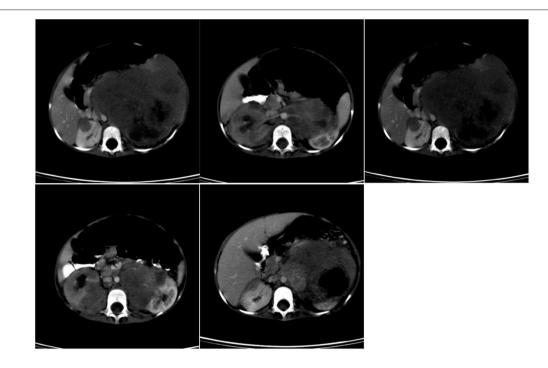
Preoperative CT scan of patient B.
